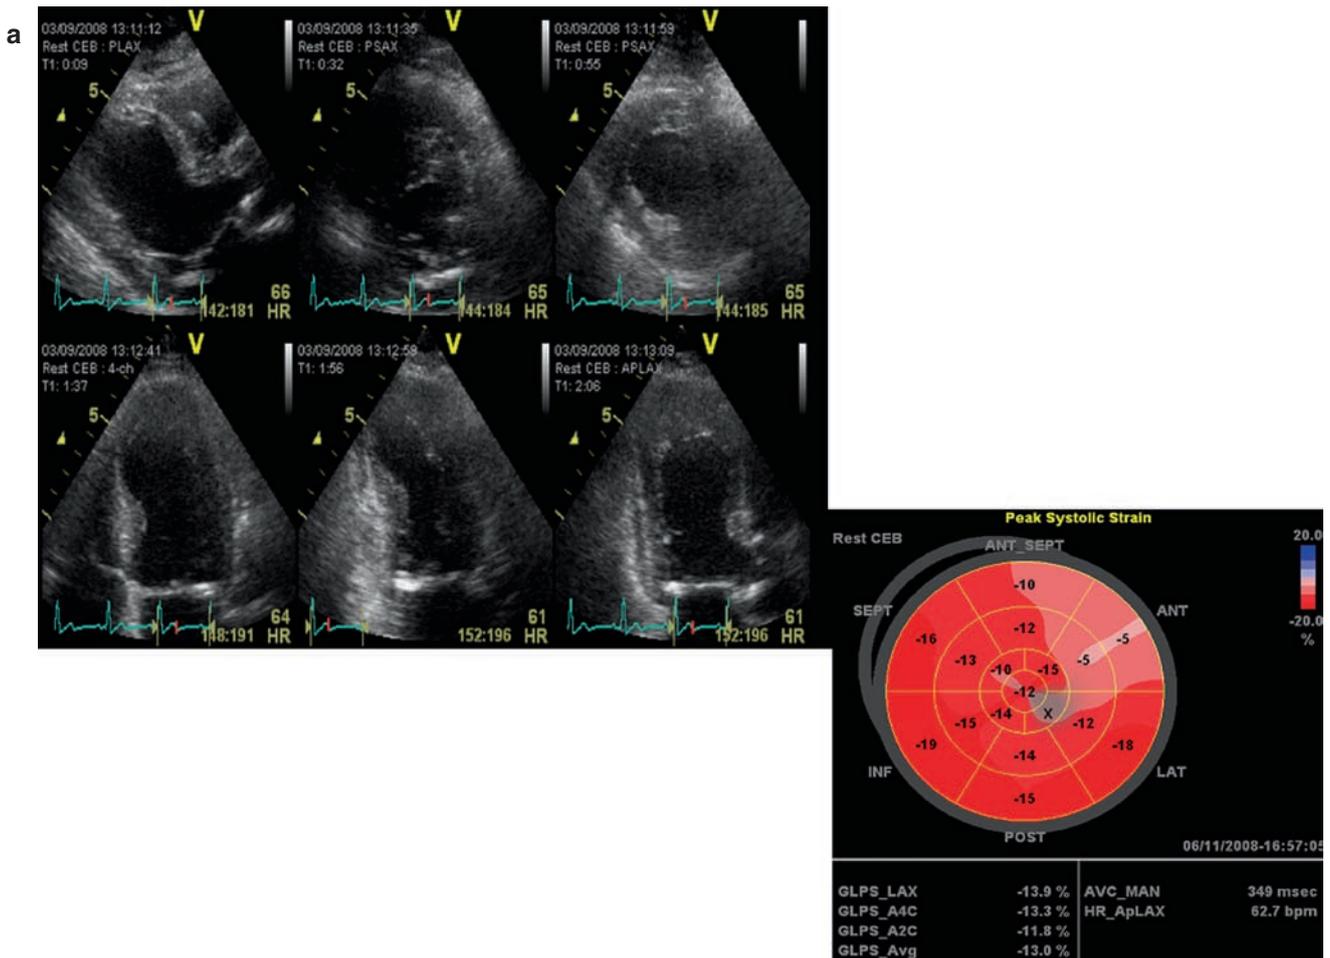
(a) Resting echocardiogram (end-systolic images) showing LV enlargement and resting wall motion abnormalities with preserved wall thickness in the antero-septum, septum, and apex. The
